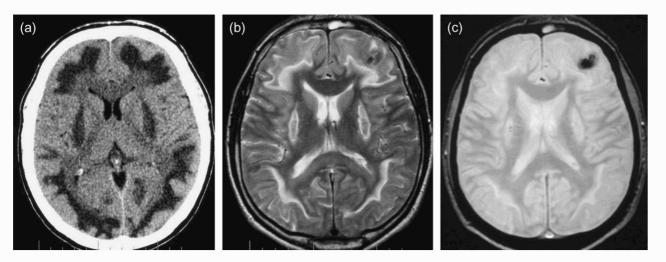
(a) Computed tomography through the level of the lentiform nuclei with marked low attenuation in the putamina and cerebral white matter. No haemorrhage is visible. (b) Long echo time (TE), long repetition time (TR) MRI at the level of the lentiform nuclei shows marked putaminal and white matter high signal. The MRI, which was carried out 5 days after the CT also shows development of a focal area of low signal in the left frontal lobe consistent with a subacute haematoma containing intracellular methaemoglobin (on short TE, short TR sequence, not shown; the haematoma showed intermediate signal with a bright rim). (c) T2* FLASH sequence with susceptibility artefact at the site of haemorhage from field inhomogeneity induced by the methaemoglobin.
